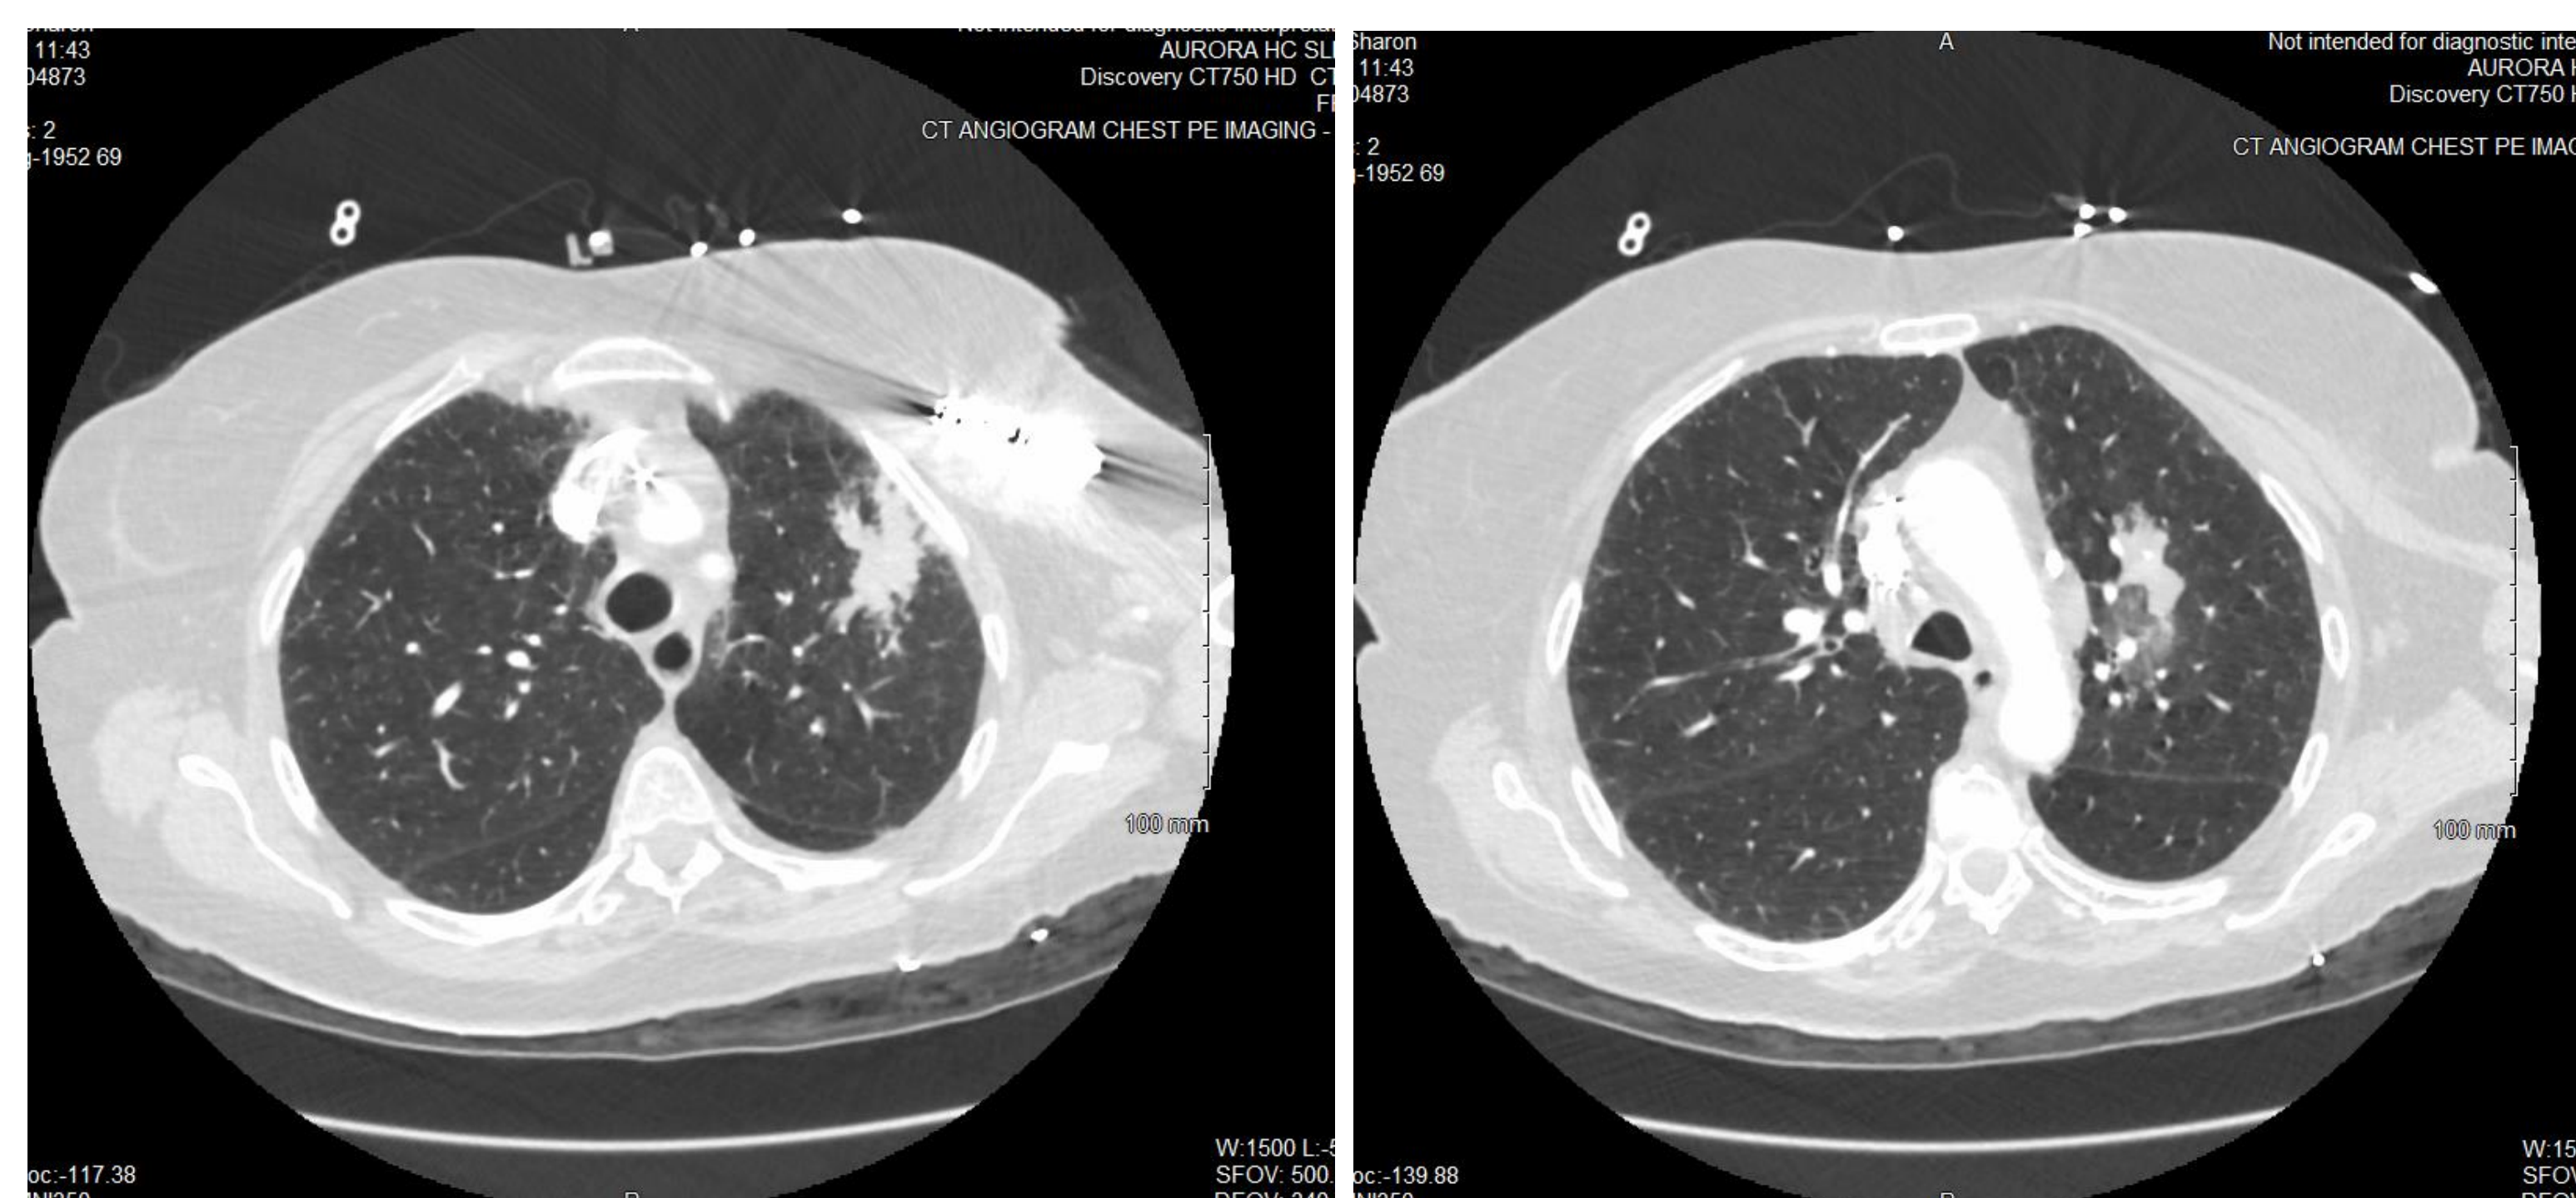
Axial CT 1 hour after pacemaker placement superior to the aortic arch
